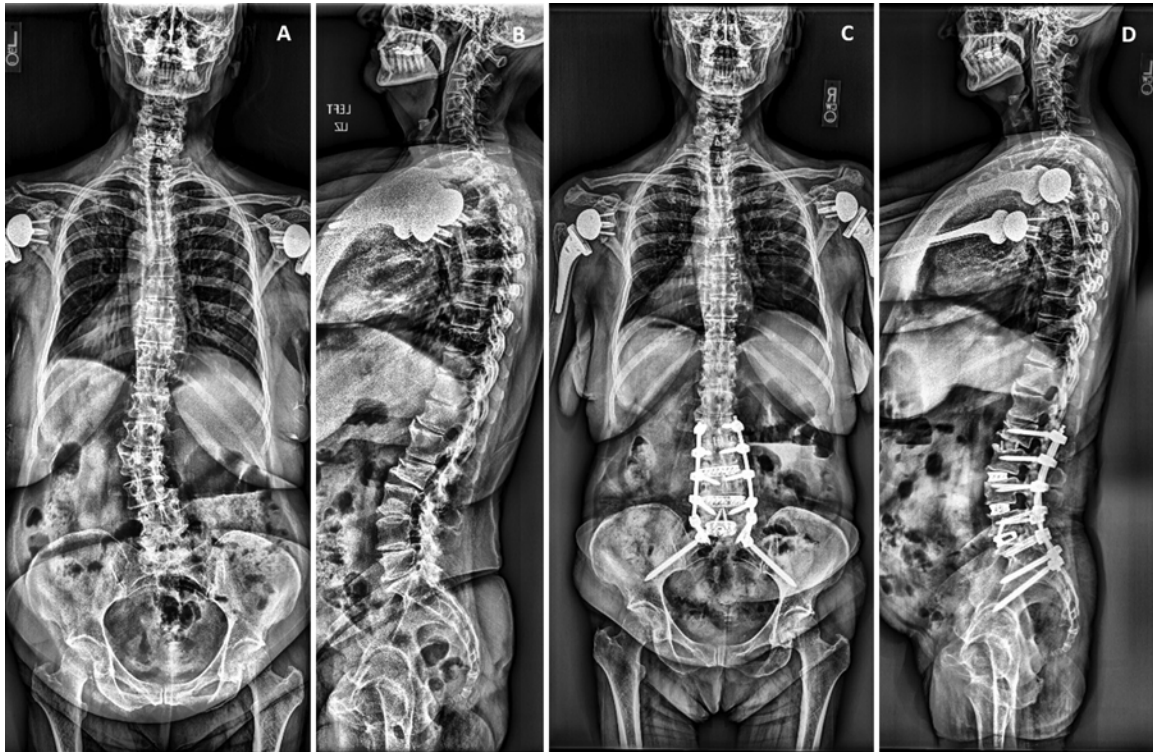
Standing radiographs (anteroposterior and lateral views, respectively) obtained in a 69-year-old female with depression at the preoperative (A and B) and postoperative (C and D) time points. This patient underwent an L2–5 LLIF, L5–S1 ALIF, and L2-pelvis MIS posterior spinal fusion.
